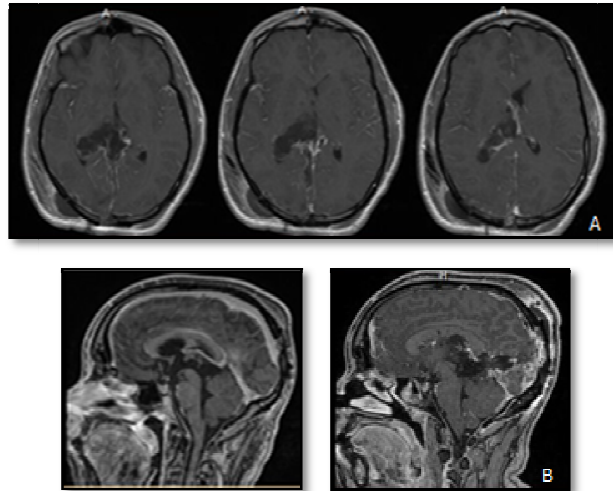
Postcontrast axial (A) and sagittal (B) MR images after subtotal resection of extraskeletal myxoid chondrosarcoma through occipital transtentorial approach
